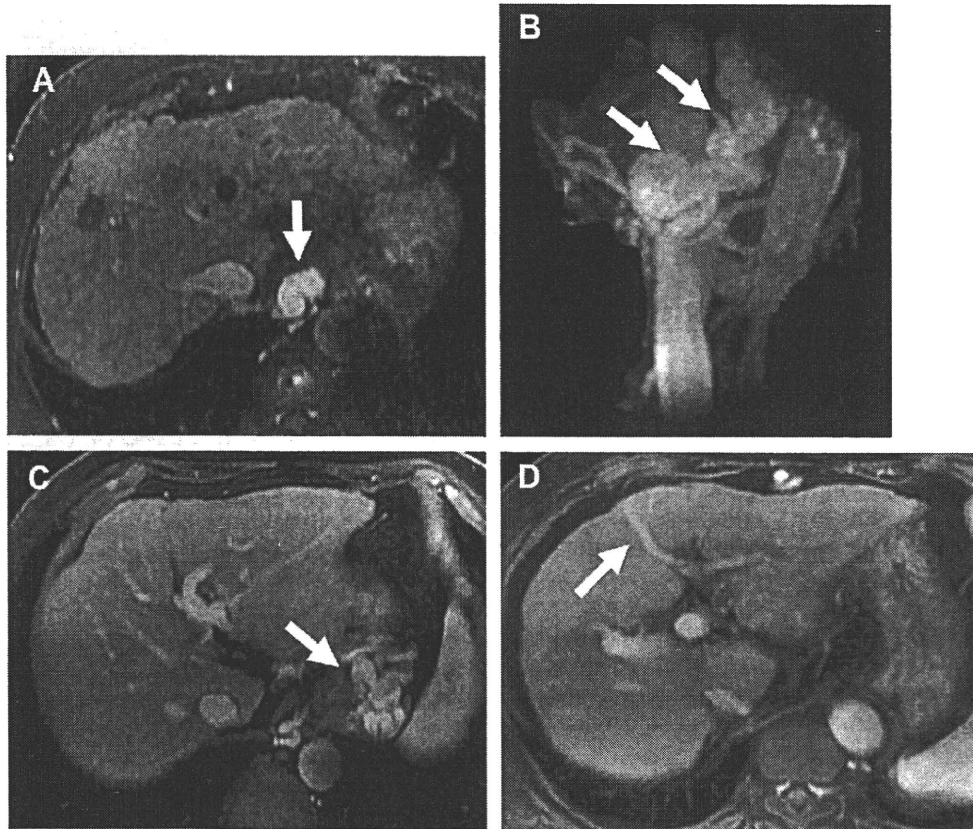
Axial T1-weighted fat-saturated 3D GRE images (TR/TE = 3.3/1.5 ms, flip angle = 12°) (A, C, D) and maximum-intensity projection image (B) in portal phase after administration of Gd-EOB-DTPA at 3-T units shows examples of collateral vessel development in end-stage cirrhosis; dilated and tortuous esophageal varices (A, B) (arrows), gastric varices (C) (arrow), and recanalized paraumbilical veins (D) (arrow).
